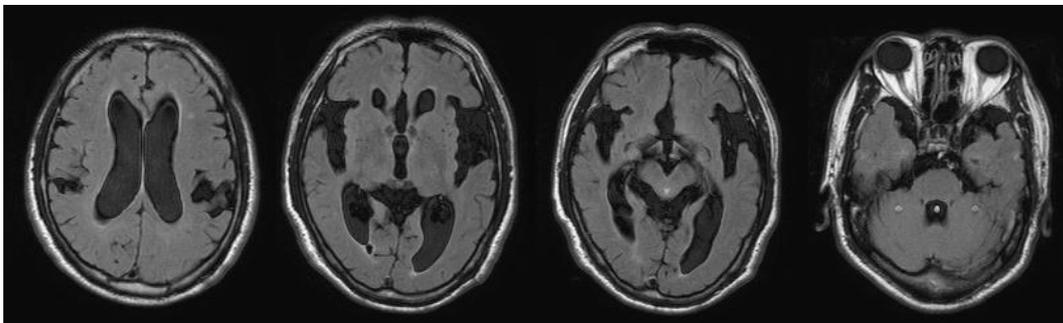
FLAIR axial MRI revealed borderline ventriculomegaly
